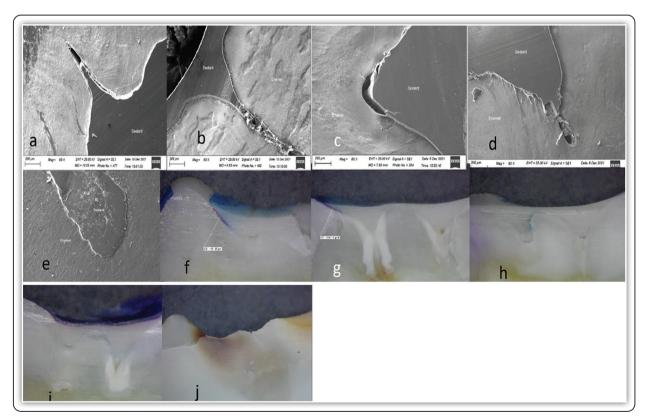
SEM photographs showing resin penetration of an Acid-etching, b, Air abrasion, c, Ultrasonic, d, Air abrasion followed by acid-etching, e, Ultrasonic followed by acid-etching, f, absence of the dye penetration at the sealant-enamel interface of Acid-etching, g, Air abrasion, h, Ultrasonic, i, Air abrasion followed by acid-etching, and j, Ultrasonic followed by acid-etching.
